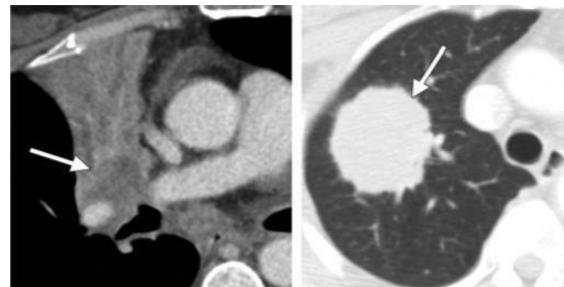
Stage T2 tumor's (chest CT scan)
